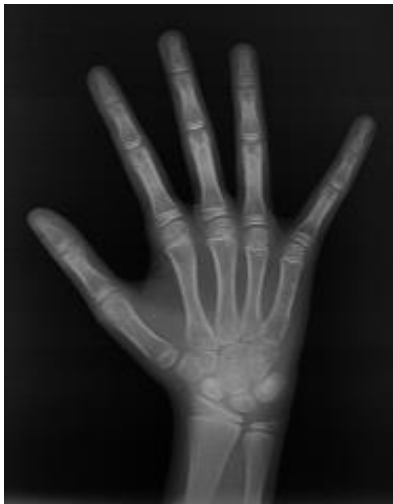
Hand-wrist radiograph.
